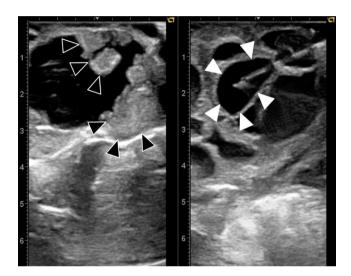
Ultrasound image of oocyte retrieval during surgery. By avoiding the suspected tumor sites (\blacktriangle), only the healthy follicles were able to be punctured (\triangle)
